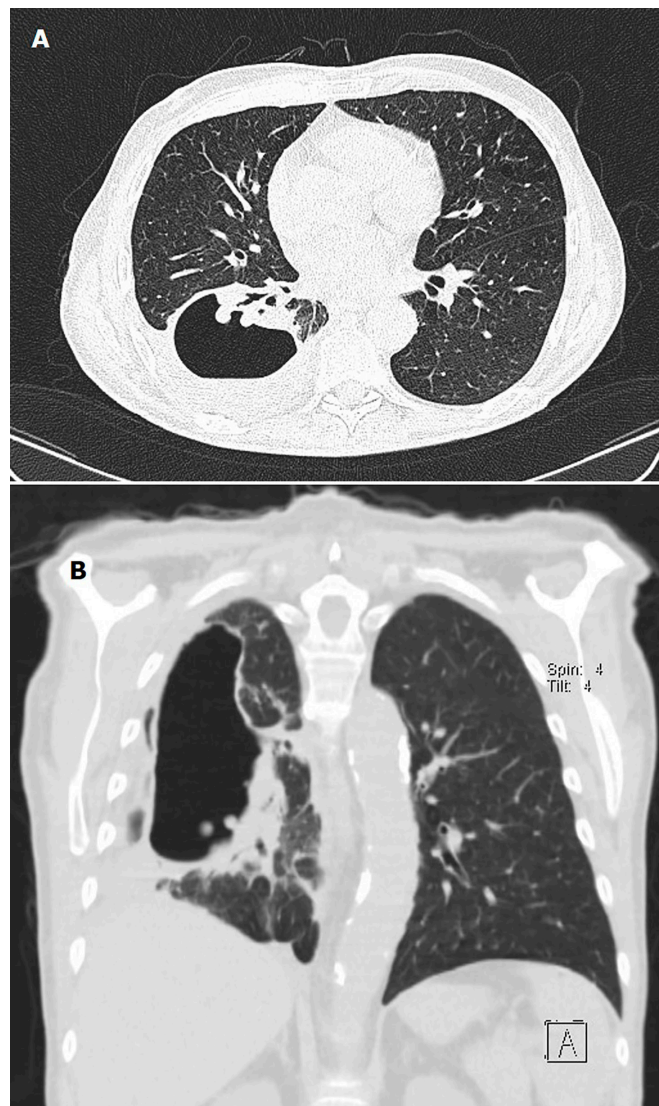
Follow-up non-contrast chest-CT performed before discharge (28 days after initial CT scan), demonstrating a reduction in the size of the abscess cavity. (A) Axial and (B) coronal views.
